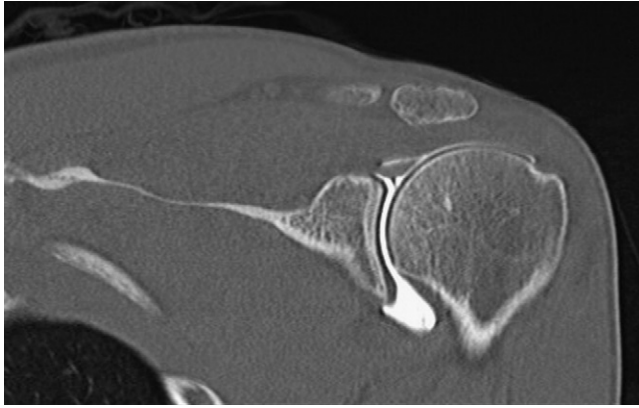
Multidetector computed tomography revealing a superior labral tear of the shoulder.
